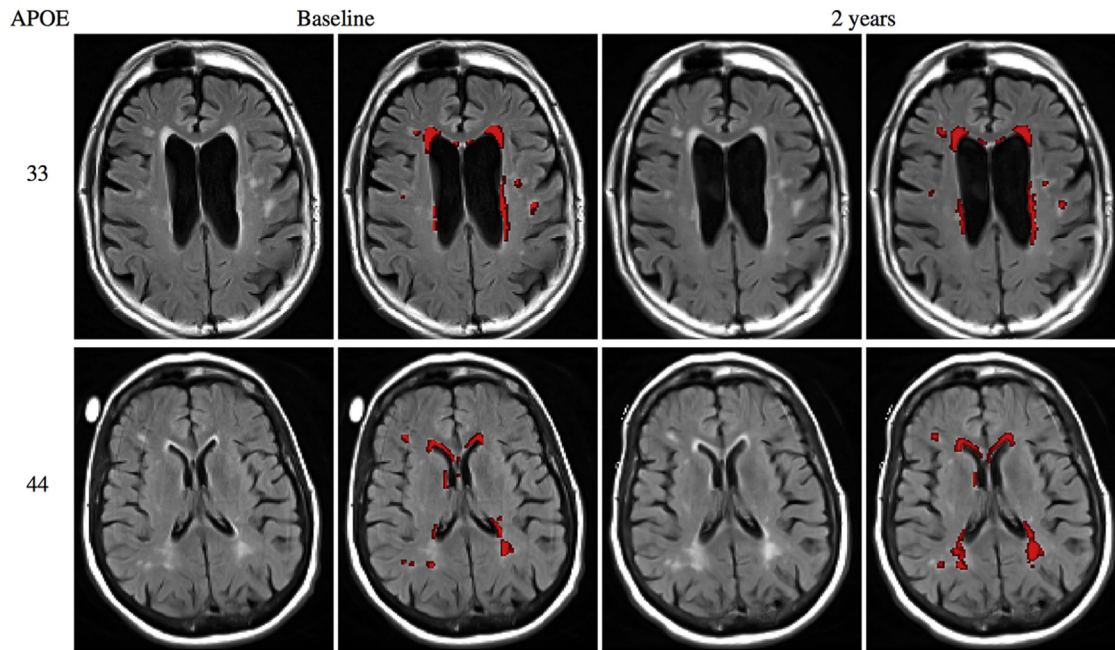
Longitudinal segmentation for 2 LMCI subjects with *APOE* status 33 (first row) and 44 (second row) with same lesion load at baseline. For each subject, the FLAIR image and the corresponding lesion segmentation (red filled) are presented for the baseline (left) and after 2 years (right). Note the faster rate of accumulation for the homozygous *APOE* $\epsilon 4\epsilon 4$ subject (right). Abbreviation: FLAIR, fluid attenuated inversion recovery; LMCI, late mild cognitive impairment. (For interpretation of the references to color in this figure legend, the reader is referred to the Web version of this article.)
